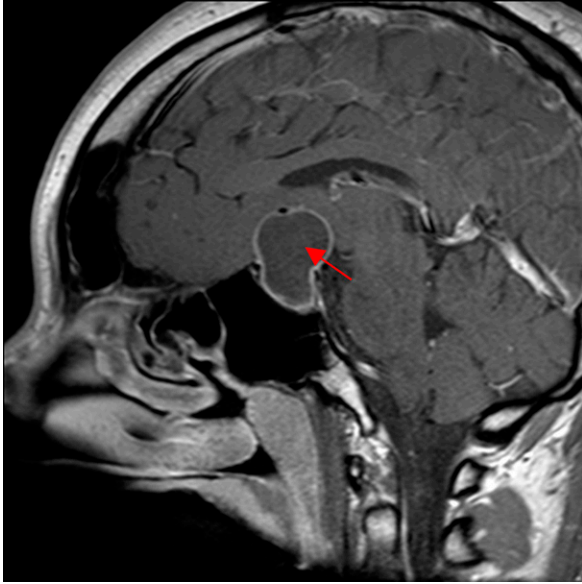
Magnetic resonance image of the brain shows a sellar mass (arrow) with suprasellar extension, consistent with either a pituitary macroadenoma or craniopharyngioma.
